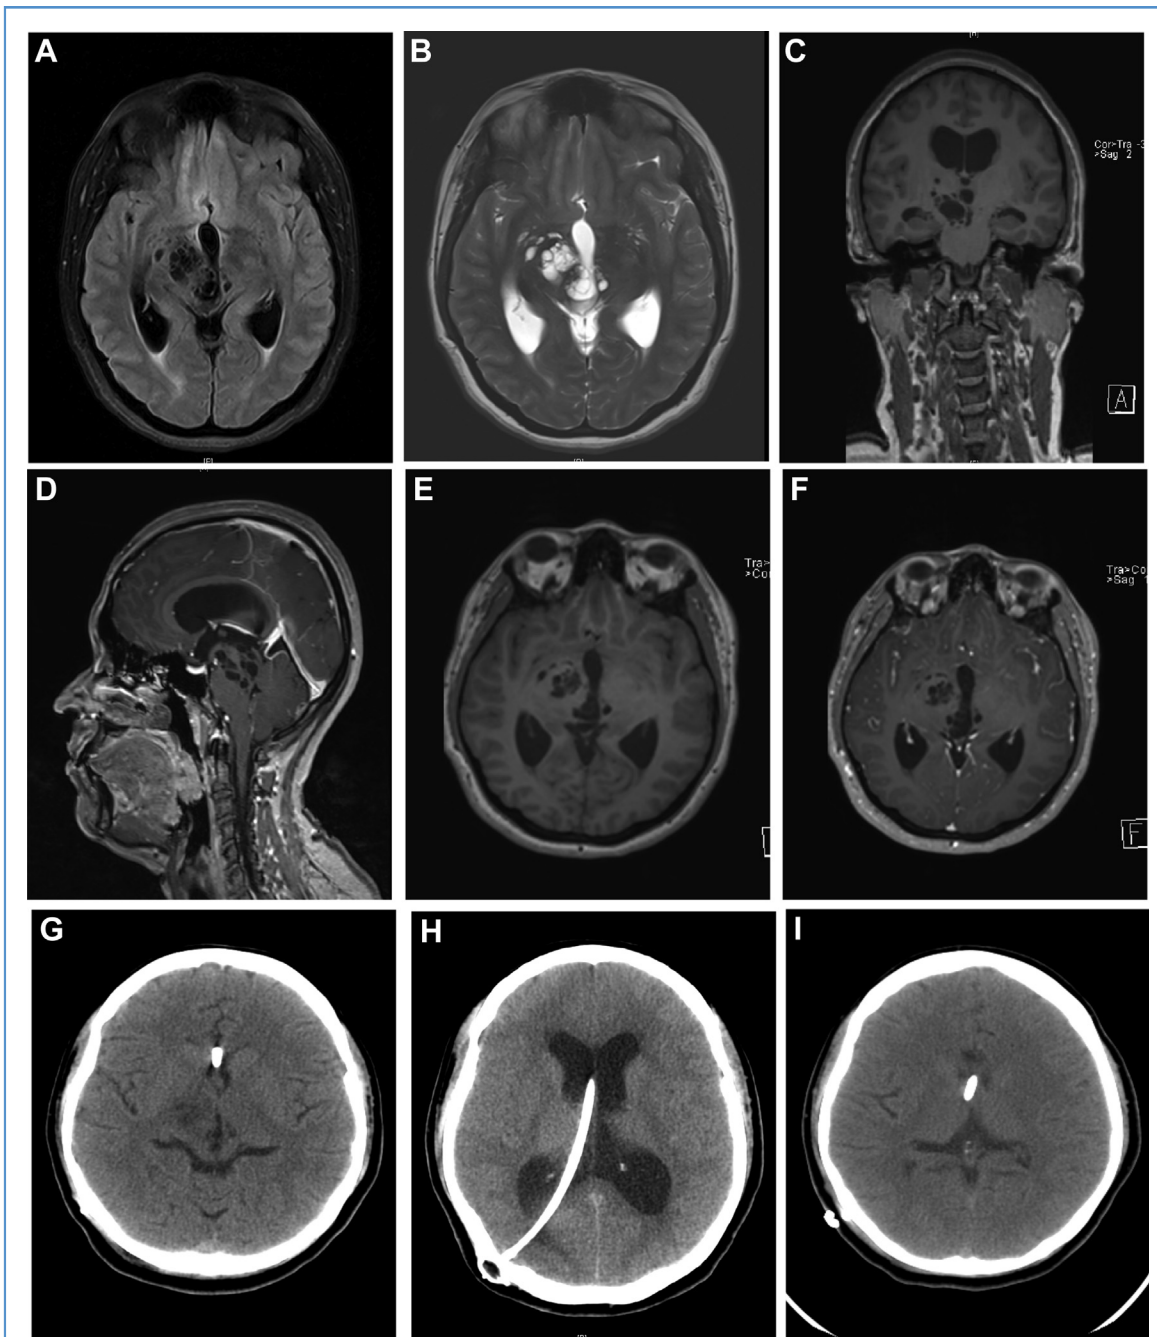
Axial fluid-attenuated inversion recovery-weighted (A), axial T2-weighted (B), coronal T1-weighted (C), sagittal T1-weighted (D), axial T1-weighted (E), and contrast-enhanced axial T1-weighted (F) magnetic resonance imaging showing a giant tumefactive perivascular space (GTPVS) in the right-sided mesencephalon and thalamus. The GTPVS is isointense relative to cerebrospinal fluid (CSF), involving and expanding into the right aspect of the midbrain with extension to the pons and thalamus on the ipsilateral side. The GTPVS is associated with supratentorial hydrocephalus. The lesion is characterized by its
